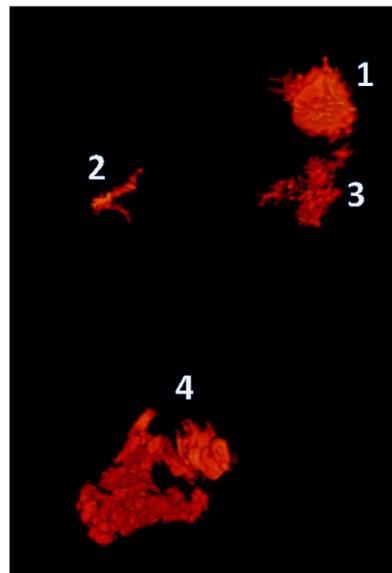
Distribution of water (red) in the gastrointestinal tract of a healthy volunteer after overnight fasting as observed by MRI (frontal view). In this example, water is present in the stomach (1: 27 mL) as well as in three “fluid pockets” located in duodenum (2: 3 mL), proximal jejunum (3: 11 mL), and terminal ileum (4: 74 mL).
